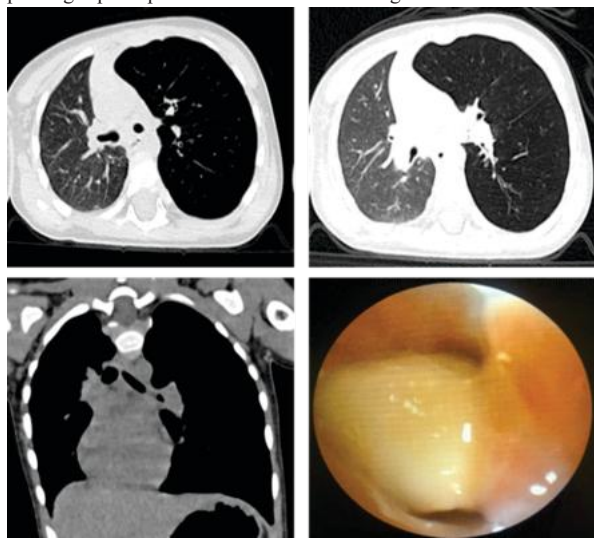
A and B) Axial plain CT thorax (lung window) views show hyperinflation of the left lung with narrowed bronchovascular markings and associated mediastinal shift to the right. Left distal main bronchus plugging seen C) Coronal plain CT thorax (mediastinal window) show plugging of the left distal main bronchus. E) Flexible bronchoscopy images shows a lodged peanut.
